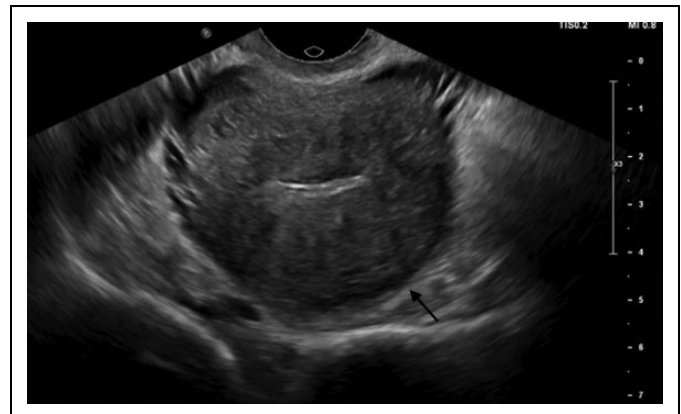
Transvaginal ultrasound showing a single echogenic, well-defined intramural mass (arrow).
